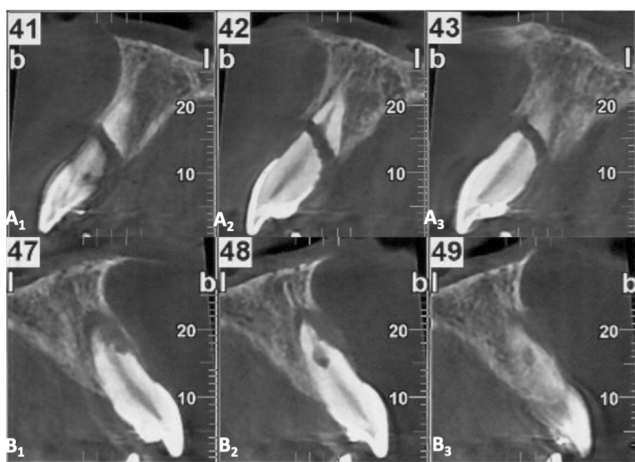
Series of the parasagittal images from CBCT of the 2 central incisors at 4 months after the injury upper row – tooth #11; lower row – tooth #21.
